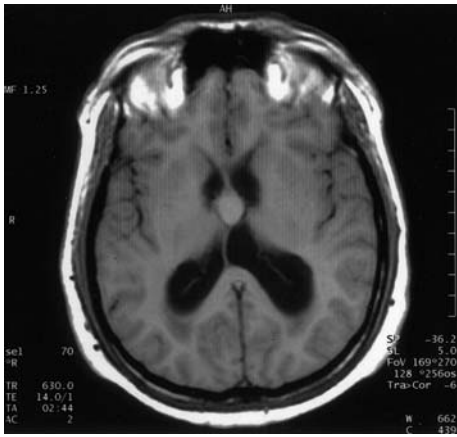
A 35-year-old male presented with headache, vomiting, and nausea. The preoperative T1-weighted axial MR image shows an isointense colloid cyst causing hydrocephalus by obstructing the foramen of Monro bilaterally
